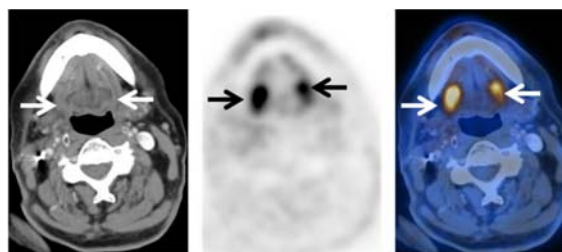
Axial images of a PET/CT study in patient with a history of treated head and neck cancer show normal FDG uptake within the tongue. (arrow) without demonstrable mass on corresponding slices CT scan
